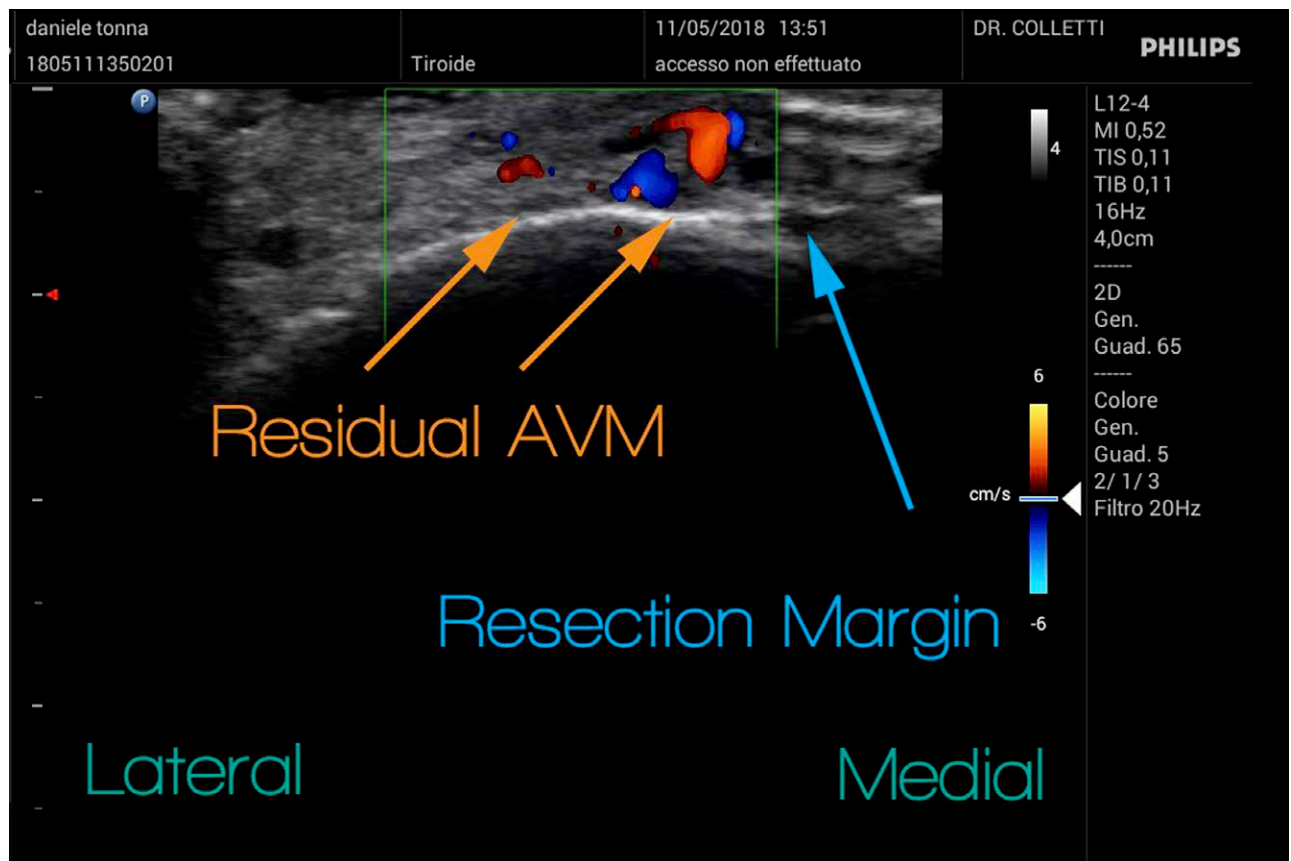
CDUS of the soft tissues lateral to the resection. AVM is still present and the exeresis extended. AVM indicates arteriovenous malformation; CDUS, Color Doppler Ultrasound.
